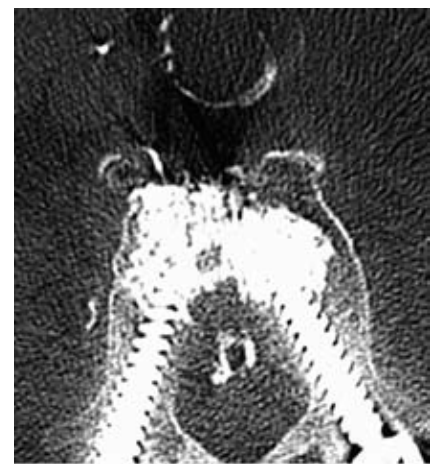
Axial computed tomography scan with bone settings at the level of the cement migration (L4) after pedicle screw augmentation showing bone cement in left laterovertbral lumbar veins, and inferior vena cava, as well as intraspinal (arrows).
